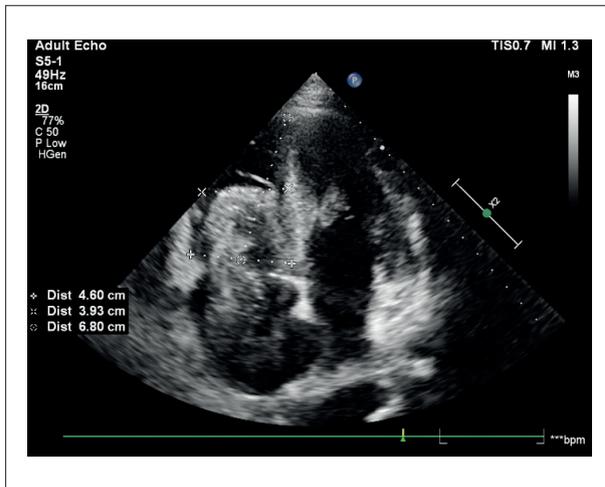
Enlargement of the right heart chambers observed in the apical four-chamber view.
